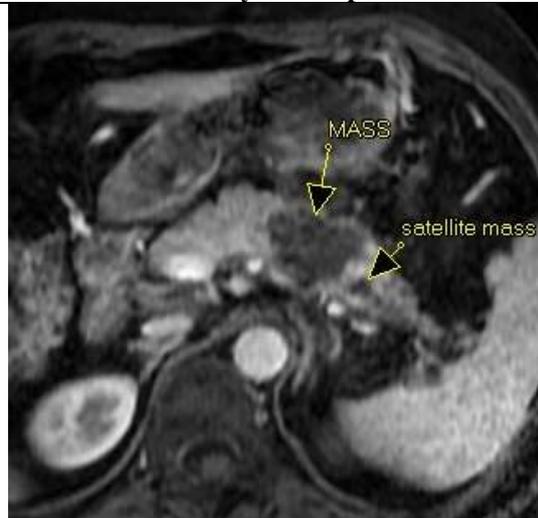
CE MRI of upper abdomen: Axial plane : Pancreas tail neoplasm with satellit mass in pancreas
